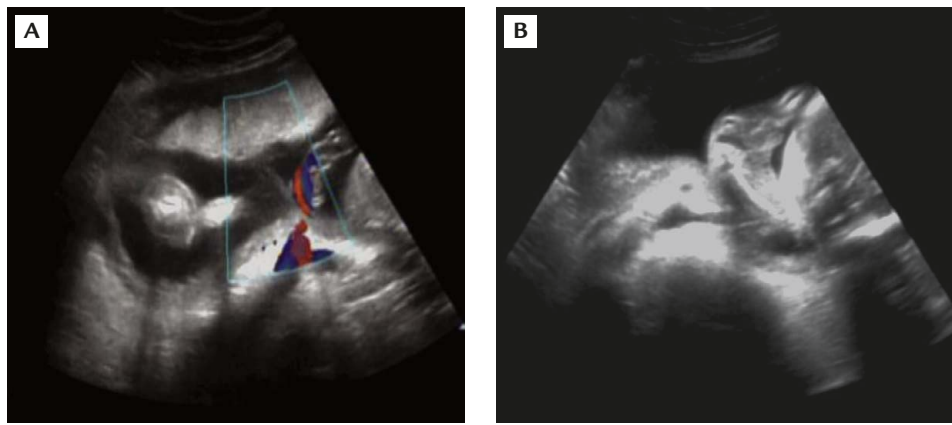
(A, B) Ultrasound shows markedly different sized umbilical cords, which may be due to them being inserted close together. No umbilical vessel retrograde blood flow of the acardiac twin is found by Doppler ultrasound.
